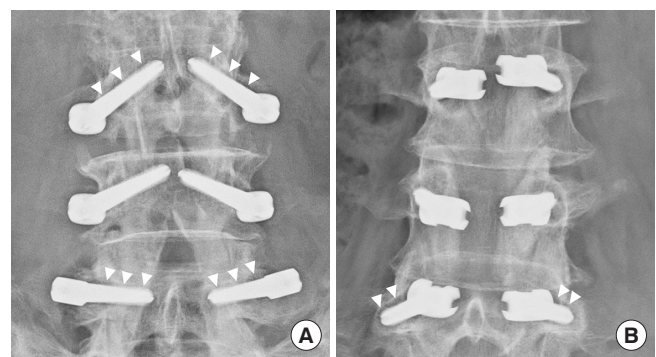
Radiographs of (A) a 73-year-old male who underwent Pedicle-based dynamic stabilization at L3-4-5, (B) a 68-year-old female who underwent cortical bone trajectory dynamic stabilization at L3-4-5. Loosened screws are documented (arrowhead).
